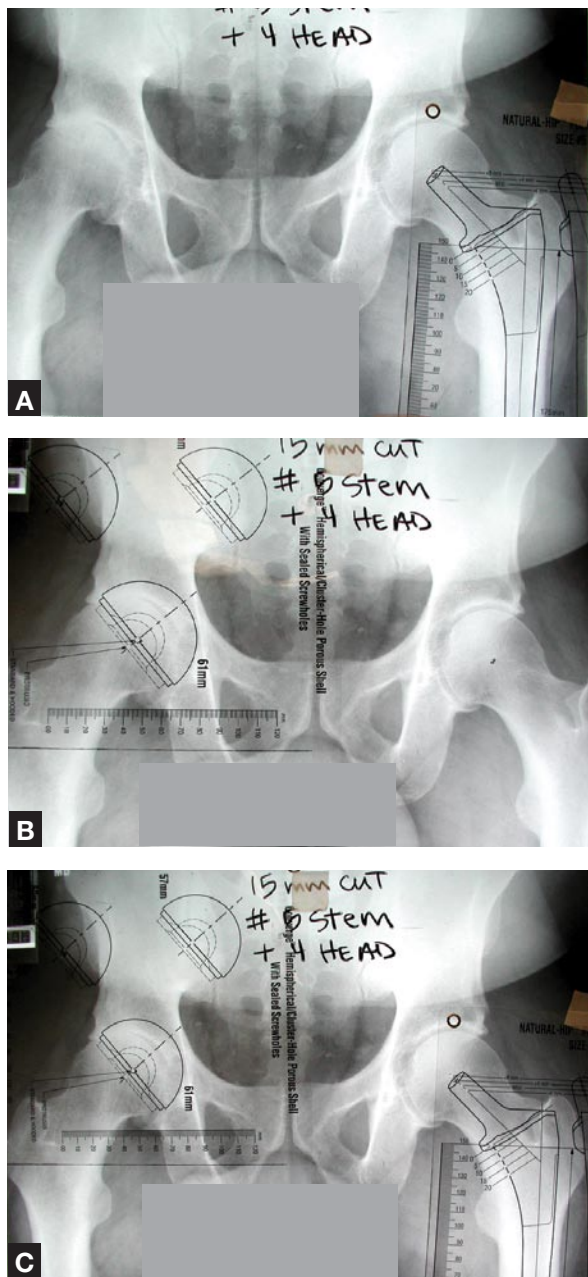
Preoperative anteroposterior pelvis x-rays of right total hip arthroplasty show (A) femoral component templated, (B) acetabular component templated, (C) acetabular and femoral components templated together.
